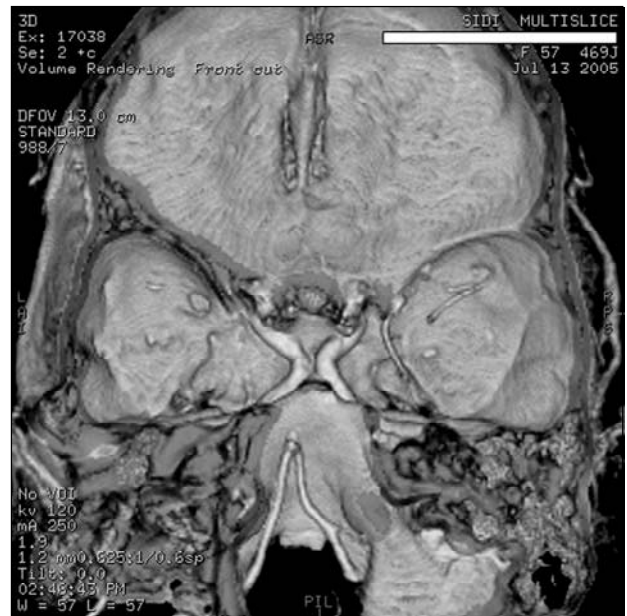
CTA – 3D Reconstruction (Axial View): Intracranial intrasellar kissing carotid arteries.
